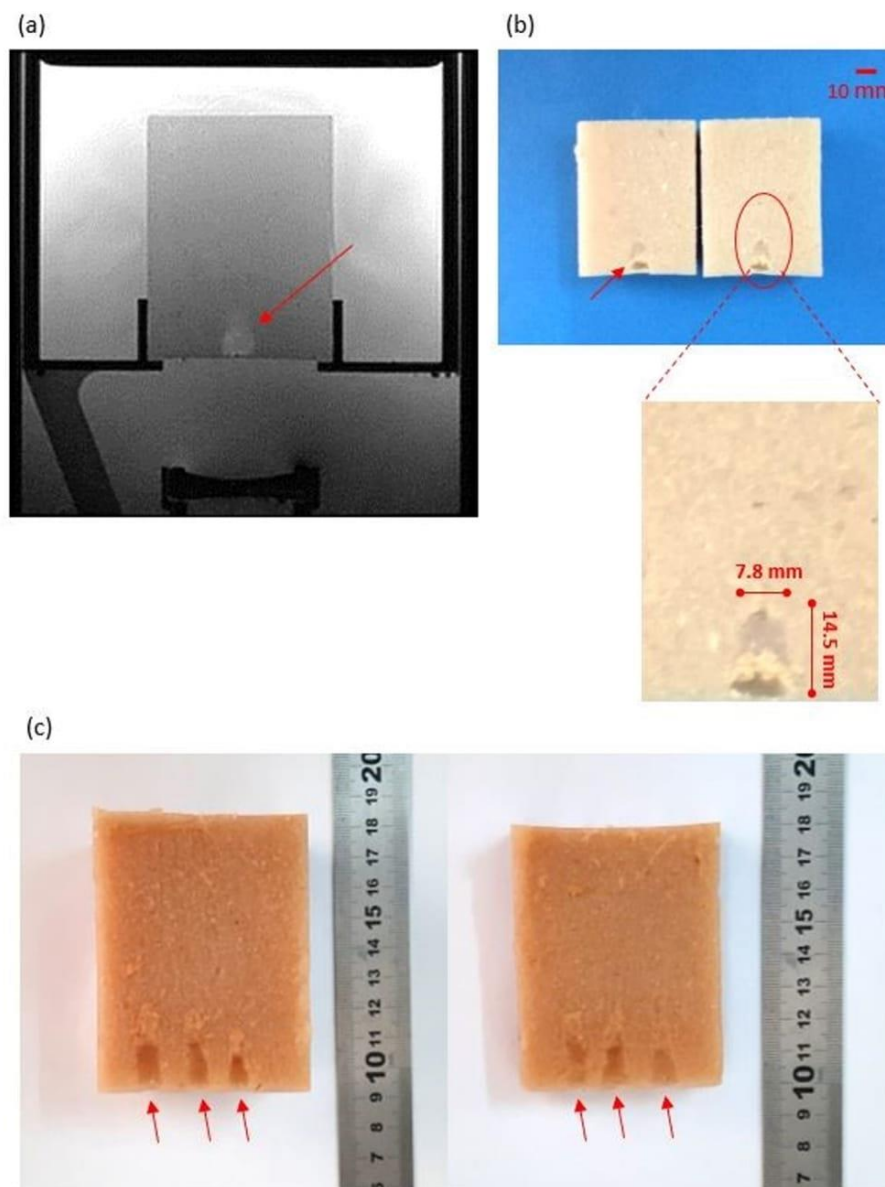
(a) PD MR image of the TMM that was obtained after the sonication of acoustic power of 44 W for 30 s using the 2.6 MHz spherically focused transducer, and (b) Photo of the sonicated area. The TMM was vertically sliced in the middle of the focal spot. A zoomed image of the sonicated area shows the created lesion and its dimensions are indicated, and (c) Multiple lesions created in the TMM. The red arrows indicate the lesions.
